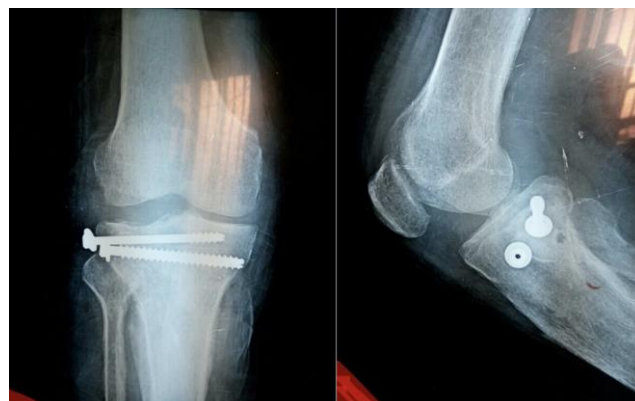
Xrays (anteroposterior and lateral views) after 1 year
